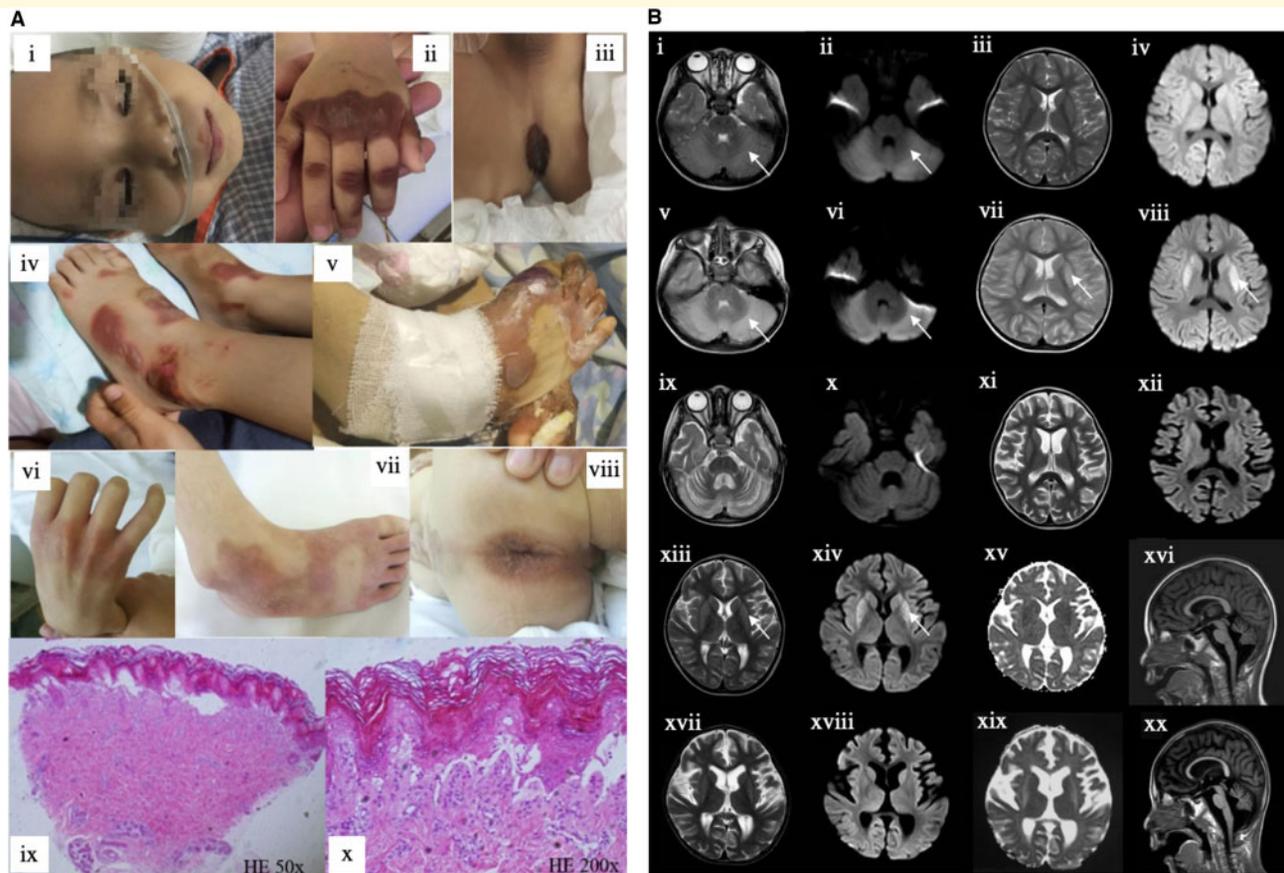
Skin manifestations and neuroimaging findings in a patient with *NAXD* mutations. (A) Skin lesions in first episode (i–iii), second episode (iv) and third episode (v). Skin lesions left pigmentation at last follow-up (vi–viii). Skin biopsies showed detachment of the epidermis from the underlying dermis with a few lymphocytes around vessels in upper dermis (ix–x). (B) Cerebral MRI five days after onset axial T₂-weighted image shows high signal (i, arrow) and increased diffusion-weighted image (DWI) signal observed in (ii) in cerebellum (arrow), and no lesions in basal ganglia (iii and iv). Repeated MRI 2 weeks later shows high T₂ signal (v, arrow) and increased DWI (vi, arrow) in cerebellum, and bilateral symmetrical basal ganglia involvement observed on T₂-weighted image (vii, arrow) and DWI (viii, arrow). Two months after onset MRI showed relief of abnormal intensity in cerebellum with mild atrophy (ix and x) and in basal ganglia (xi and xii). One year after onset MRI axial T₂-weighted image shows mild high signal (xiii, arrow), increased DWI signal (xiv, arrow), decreased apparent diffusion coefficient (ADC) in bilateral symmetrical basal ganglia (xvii), and cerebellum atrophy in sagittal T₁-weighted image (xx). Two years and 2 months after onset (at last follow-up) demonstrated relief of abnormal signals in bilateral basal ganglia with brain atrophy (xvii–ix) and worsening of cerebellum atrophy (xvi).
